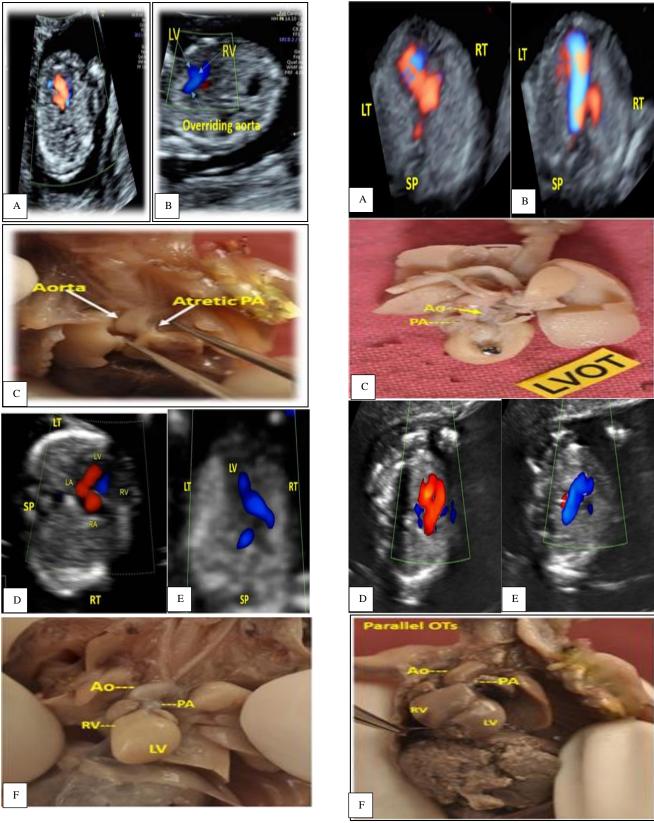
(A-F): Complete agreement-full agreement between ultrasound and autopsy-cases from excel sheet. Two inflows, single outflow tract (Aortic override with pulmonary atresia), tetrology of Fallot with pulmonary hypoplasia. Single inflow across left AV valve, single outflow (Aorta) from left ventricle and hypoplastic right heart syndrome.
